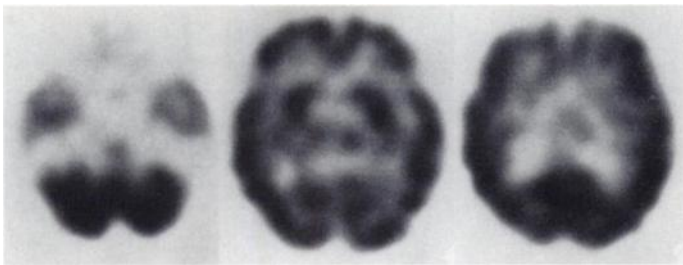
Technetium-99m-HMPAO brain SPECT shows normal perfusion image.
